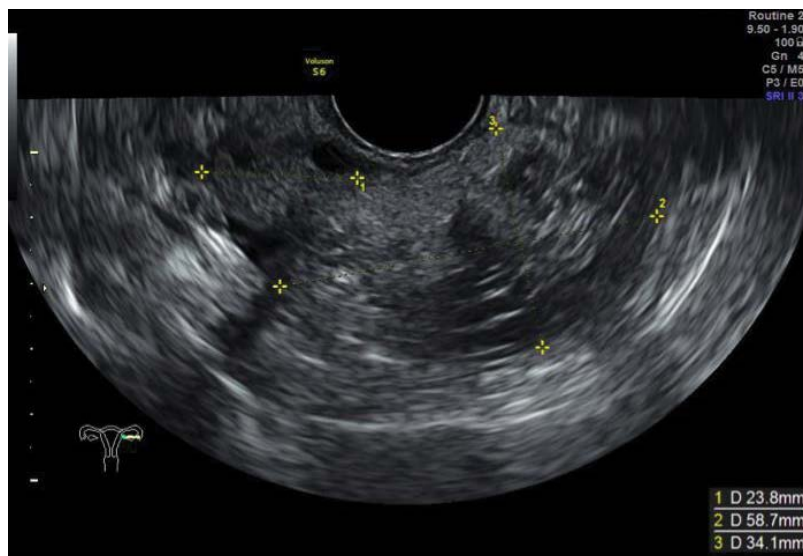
Transvaginal sonography at 7 months postpartum showing a 58.7 × 34.1 mm ovarian mass and 23.8 mm normal part of the left ovary.
